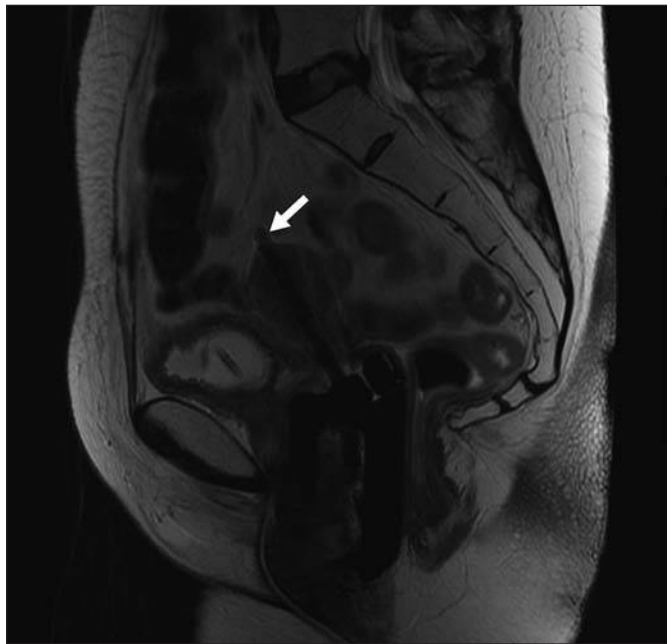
47-year-old woman with cervical cancer. Sagittal T2-weighted MR image shows that applicator tip of intracavitary brachytherapy probe has perforated fundus of uterus (*arrow*).
